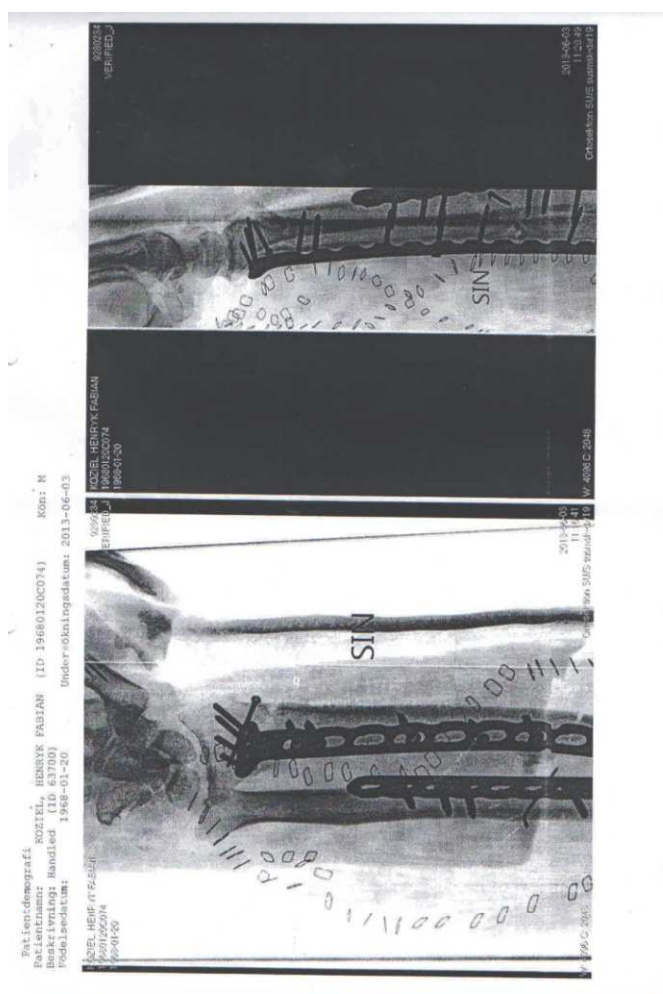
Postoperative radiographs of the forearm
